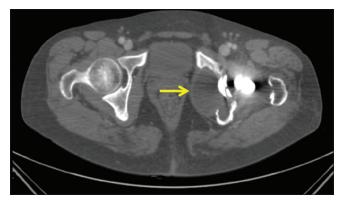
Computed tomography scan showing a large fluid filled mass (arrow) of soft tissue in the left intrapelvic region
